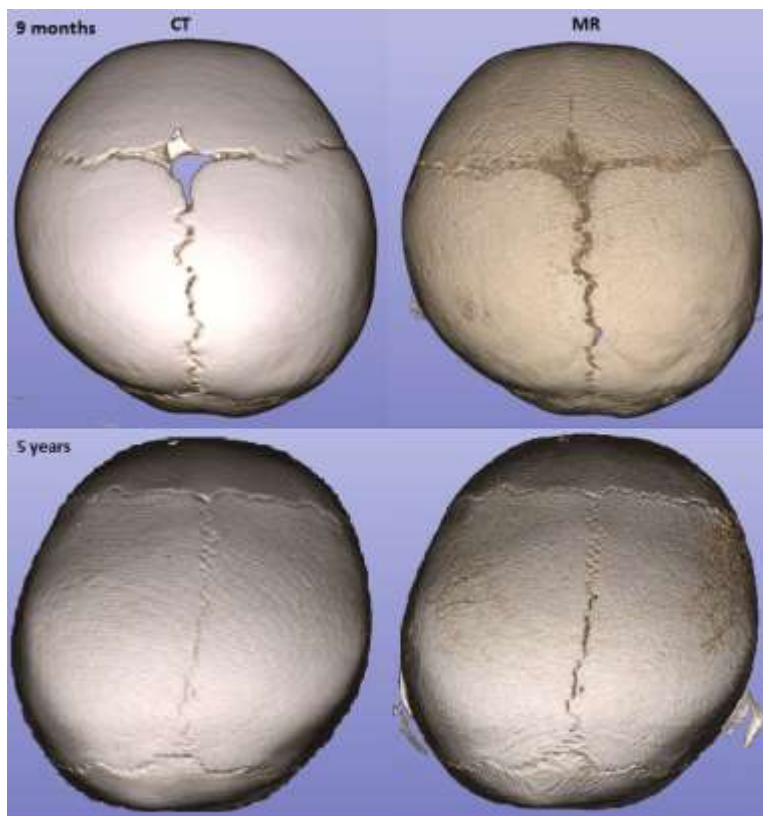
Matching CT (left) and MR (right) images for 9-months (top) and 5-years (bottom)
